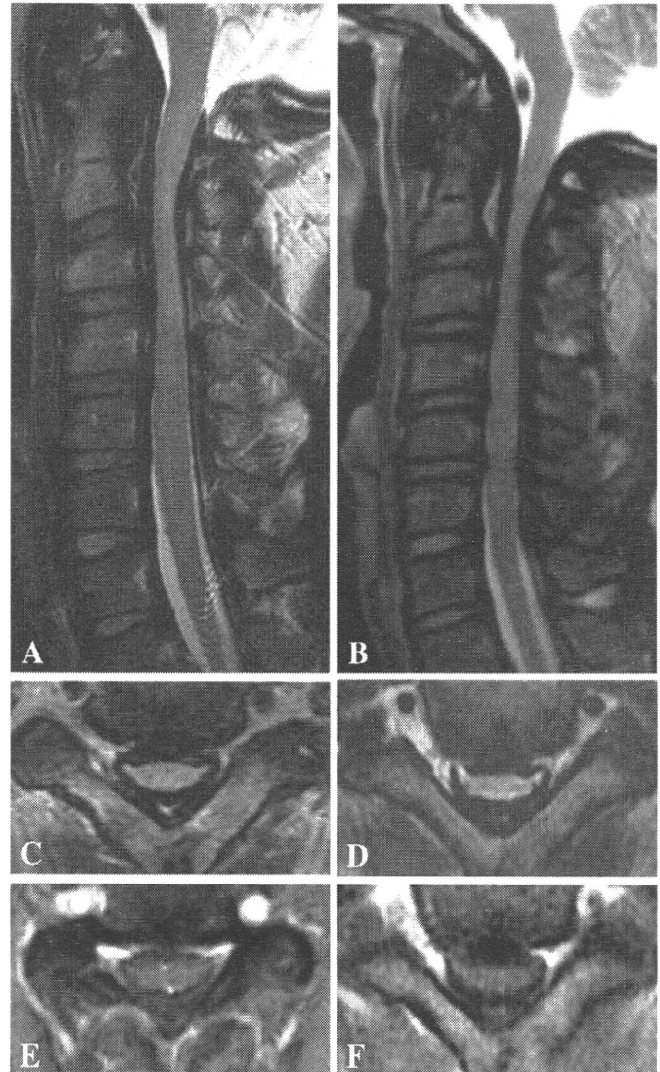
MRI of the cervical spine of Patients 1 (A, C, E) and 2 (B, D, F) showed severe cord compression at C2–6, surrounded by thickened dura mater. The thickened dura was characterized by hypointensities on both T1- and T2-weighted images, but there was no gadolinium enhancement (A–D: T2-weighted image; E, F: T1-weighted image with gadolinium enhancement; C–F: axial sections at C2/3 level).
